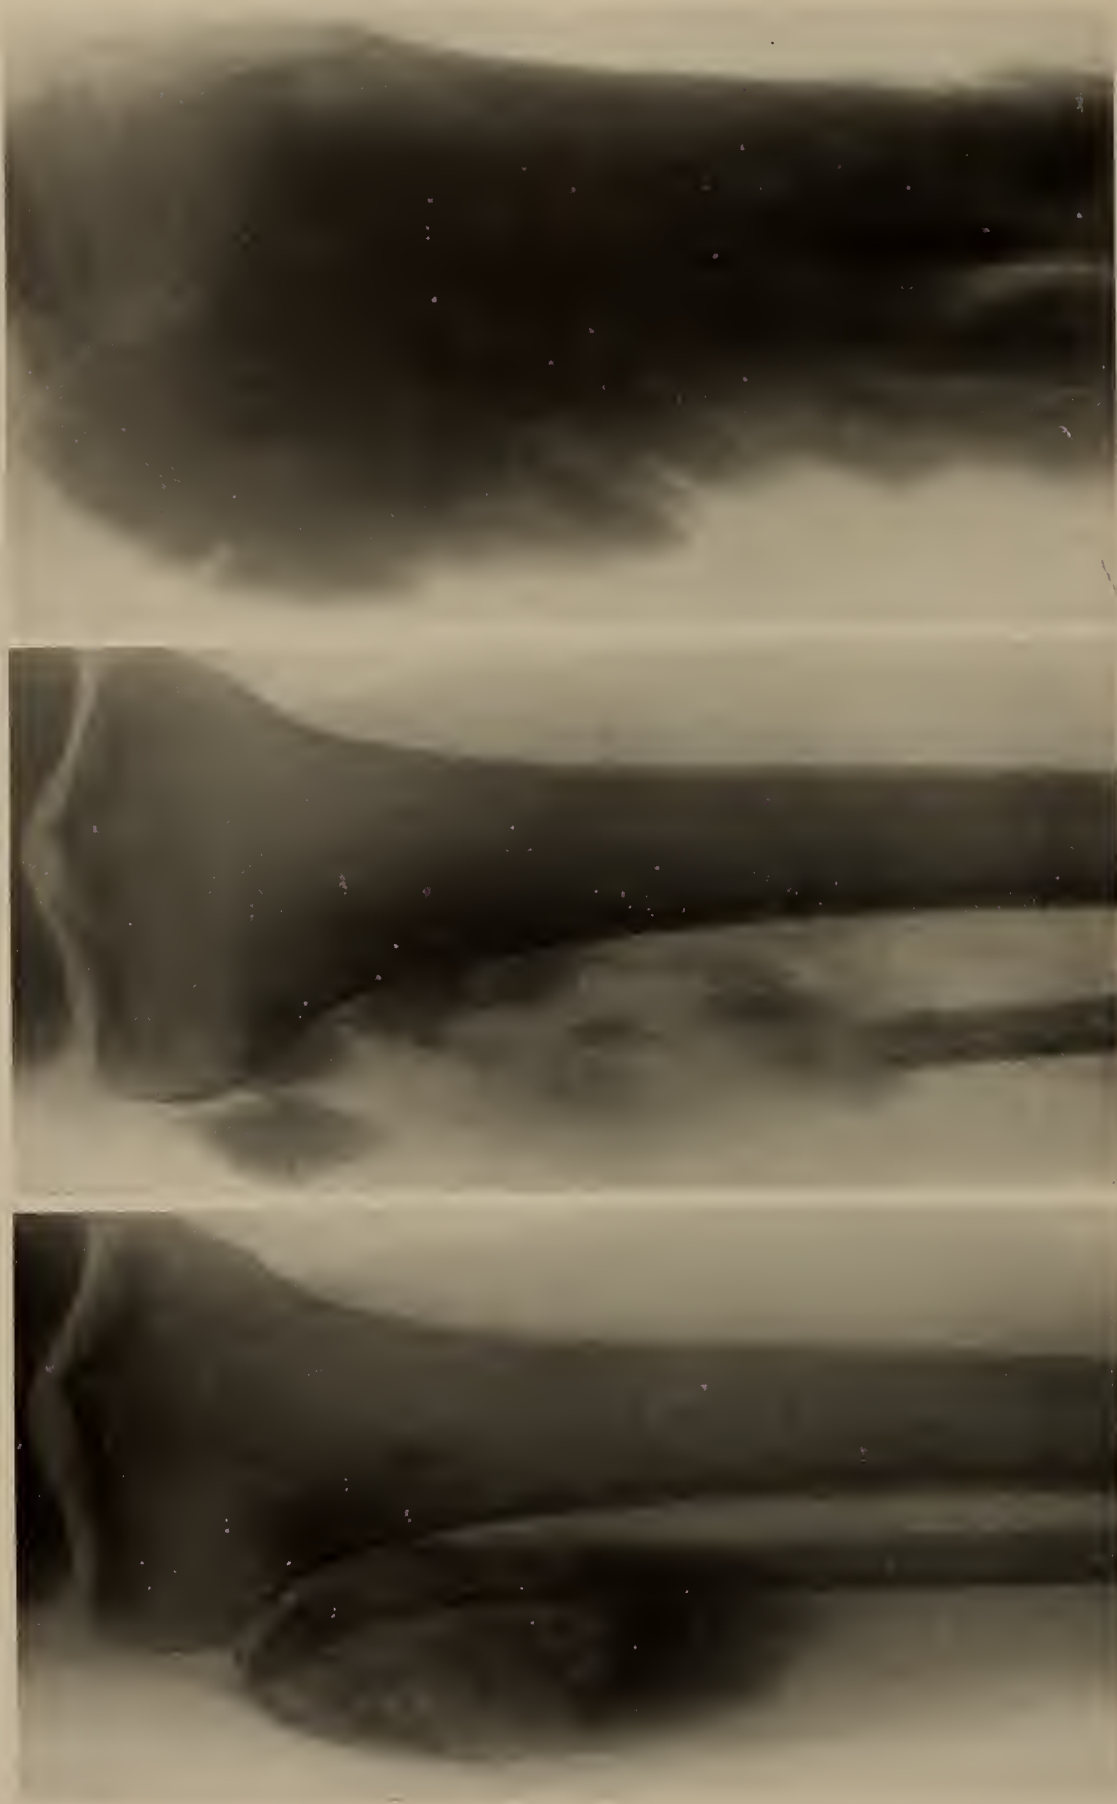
Case 263. Myositis ossificans in a man 34 years old. The onset in July, 1919, with a tumor of the fibula (roentgenogram 1). In November, 1919, the involved part of the fibula was resected, but in February, 1921, a recurrence was noticed (roentgenogram 2). In February, 1923, an amputation was performed (roentgenogram 3). Notice the striations of the ossified muscle bundles. This case was interpreted by some pathologists as an osteogenic sarcoma.
